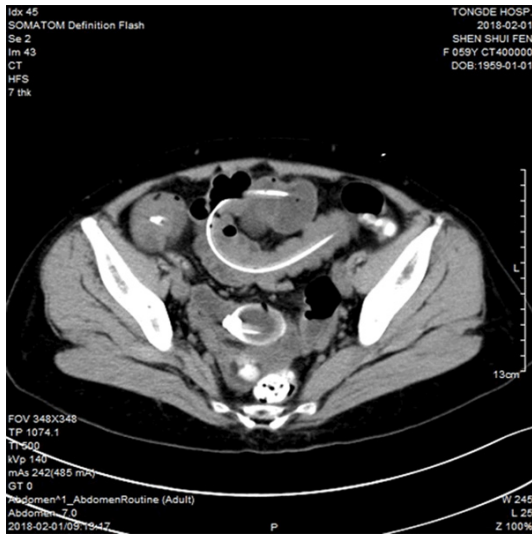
Abdomen CT after stone extraction, and the dilated intestines were relieved.
